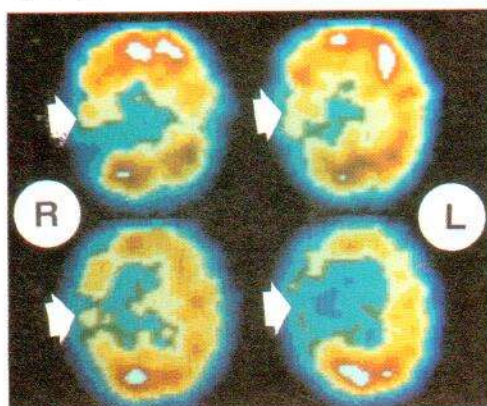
14-year-old girl with cerebral infarction. SPECT showed large area of hypoperfusion corresponding to vascular territory of right medial cerebral artery.
